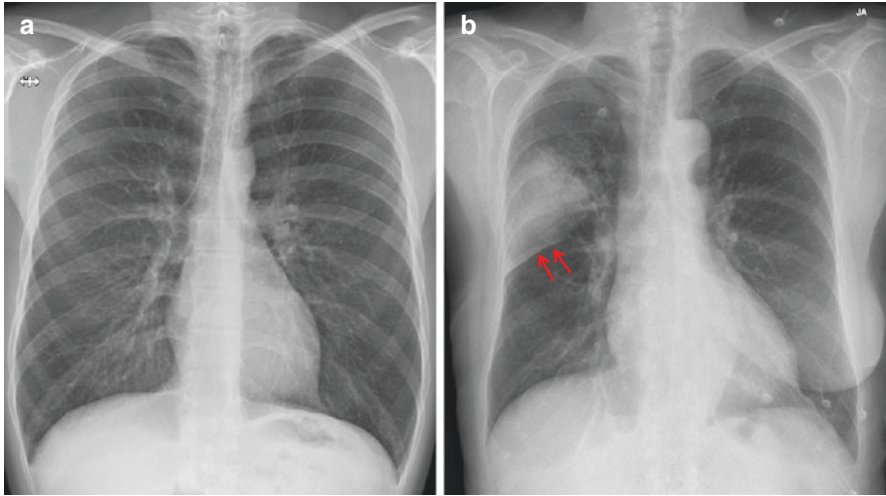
(a) Normal Chest Radiograph (b) Right upper lobe consolidation abutting the superior aspect of the horizontal fissure (red arrows)
